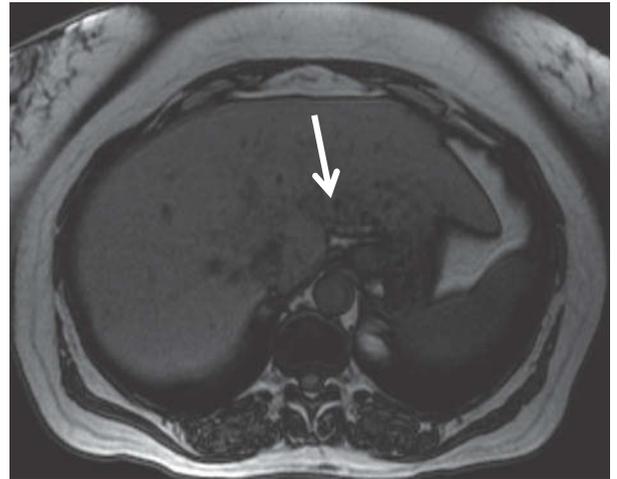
Focal fatty sparing. Axial, T1-weighted, fat-saturated in-phase (A) and out-of-phase (B) images demonstrate marked loss in hepatic signal compared to the spleen compatible with hepatic steatosis. Arrows indicate geographic area of bright signal (B) compatible with focal fatty sparing.
